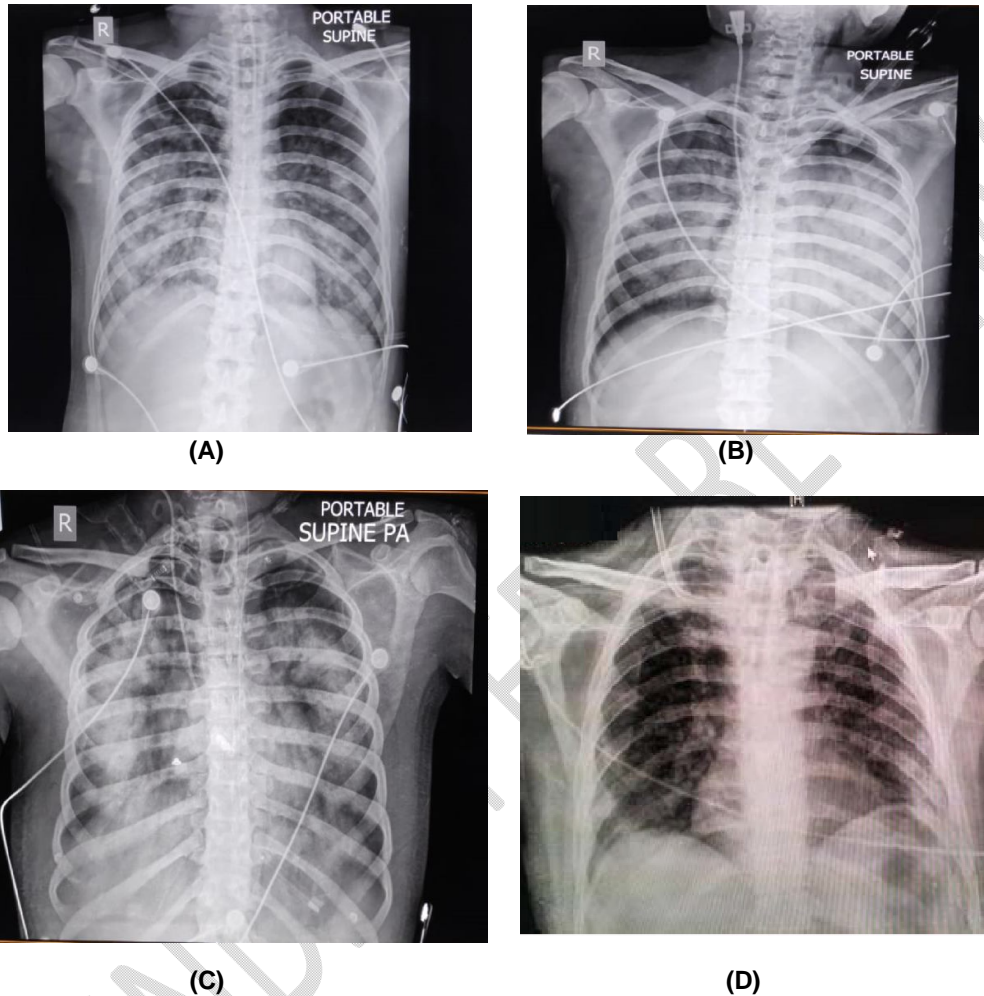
Figure A-D: Shows serial Chest X-ray done on Admission (A) During the course of treatment (B) and (C) Bilateral increased homogenous opacities in line with clinical picture of ARDS followed by (D) which shows significant improvement post tracheostomy decannulation at the time of discharge.
